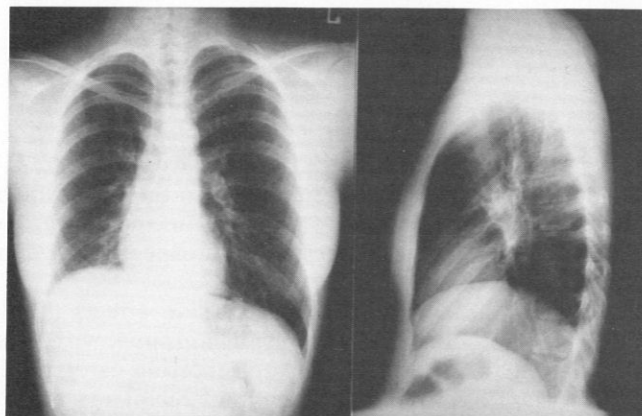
Pre-therapy roentgenograms of the postero-anterior and lateral chest show marked volume loss on the right side of the chest. Note mediastinal shift to the right and marked elevation of right hemidiaphragm.
